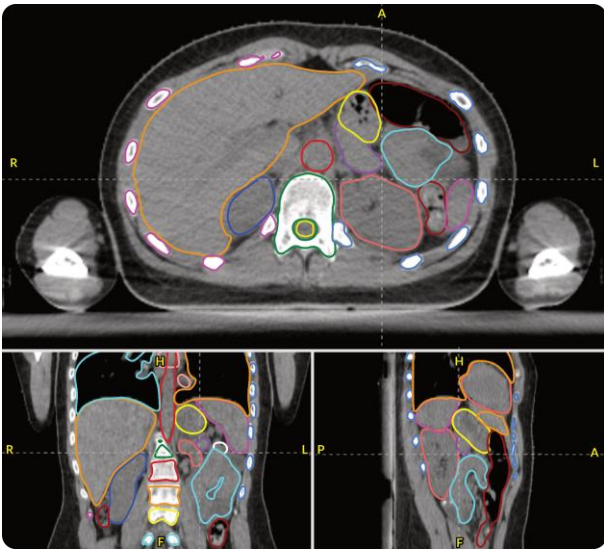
AutoContour user interface with CT contours.
